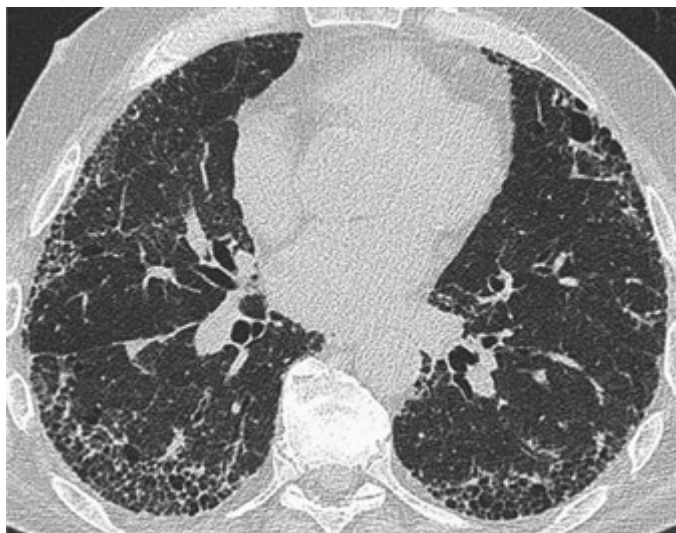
HRCT scan of a patient with biopsy-proven IPF. Appearances are typical of IPF with a subpleural distribution of microcystic and macrocystic honeycomb change.
